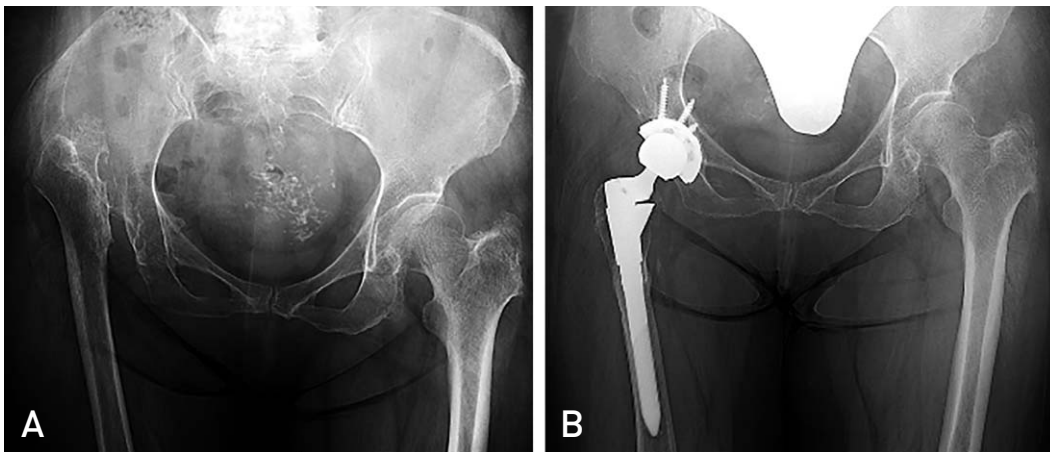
Preoperative (A) and postoperative (B) radiographs of a 67-year-old female patient with Crowe IV developmental dysplasia of the hip. A 50-mm cup was placed below the anatomical acetabulum.
